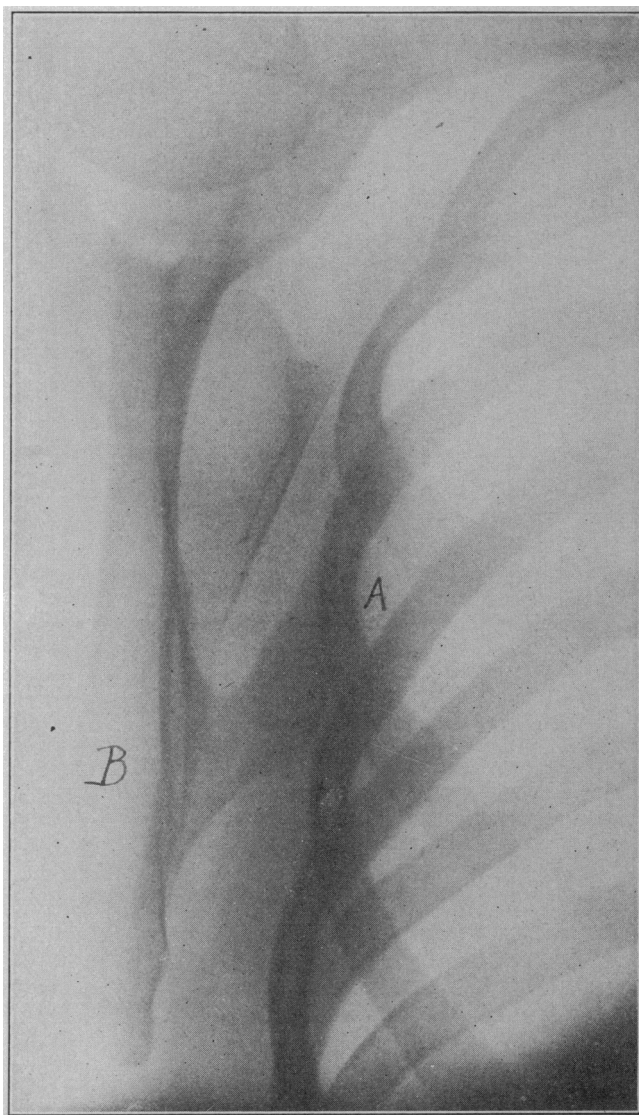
Roentgenogram of inner surface of scapula. A, B, exostosis. A is free end of exostosis covered by shadow of rib.
